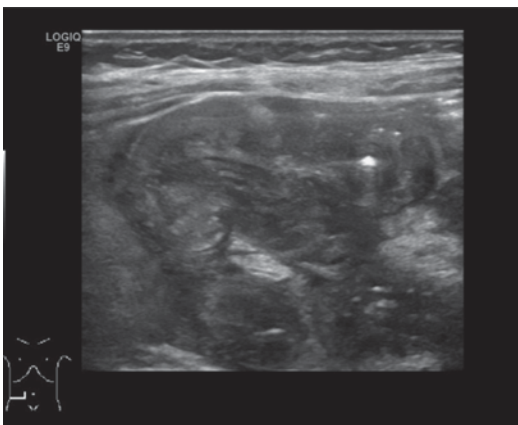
Malrotation with volvulus—color Doppler ultrasound demonstrates “whirlpool” sign
